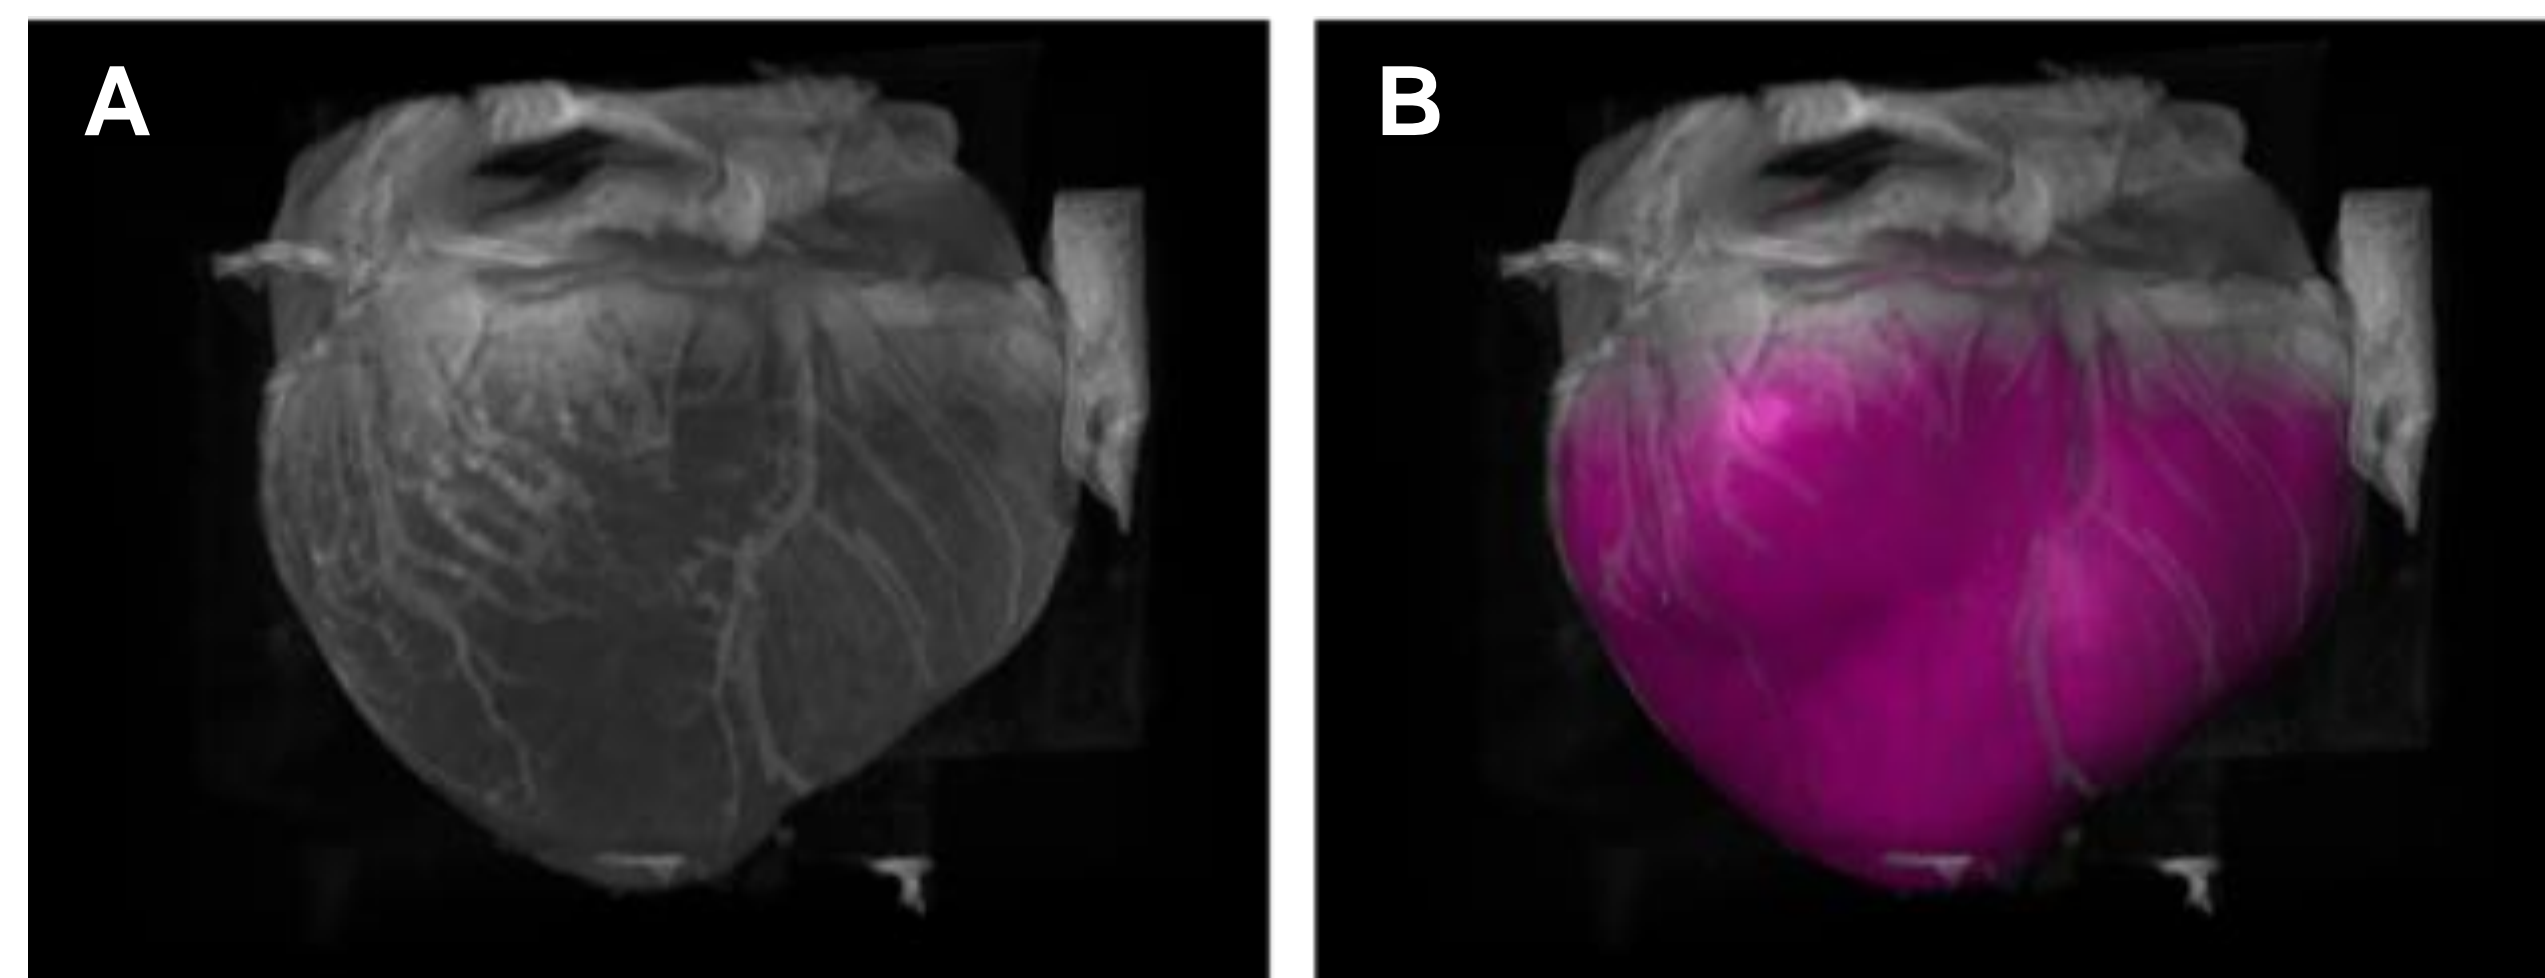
(A): 3D constructed visualization of the ventricular structure from MRI data. (B): The FE geometric segmentation of the ventricular structure over the same background MRI data.
